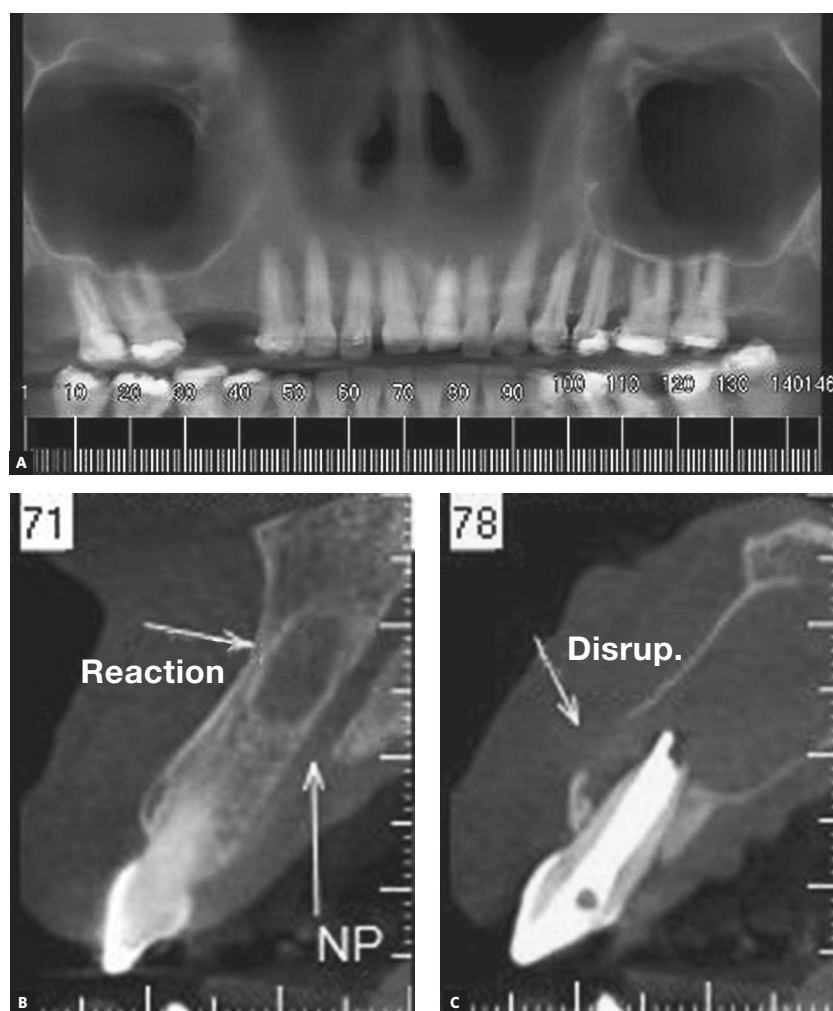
Initial radiograph showing the extent of the lesion (A). Computed tomography: lesion in close contact with the apex (B); and disruption of the vestibular cortical bone (C).
